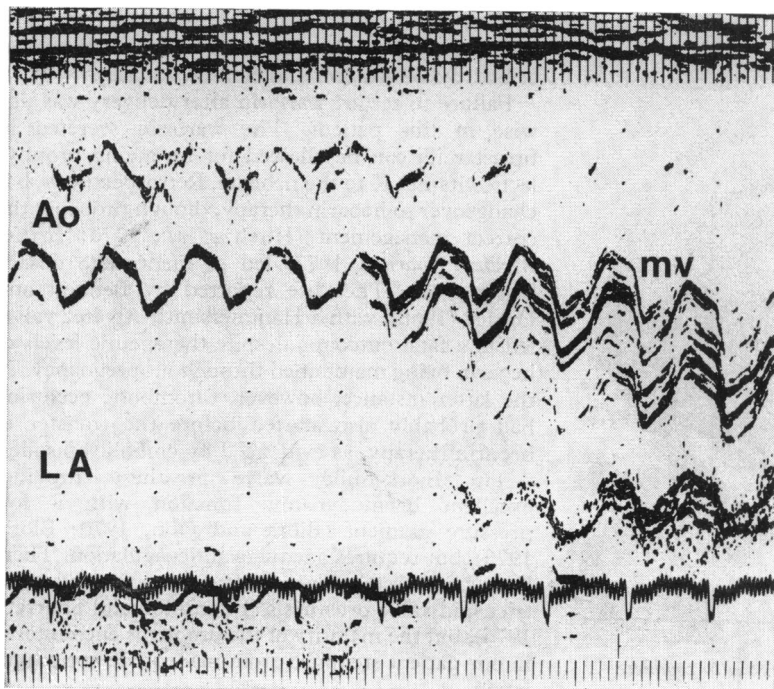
Echocardiogram showing reduced excursion of Björk-Shiley mitral valve prosthesis (mv), with reduced opening and closure rates. The left atrium is greatly enlarged. LA, left atrium; Ao, aortic root; depth marks at 1 cm intervals.
